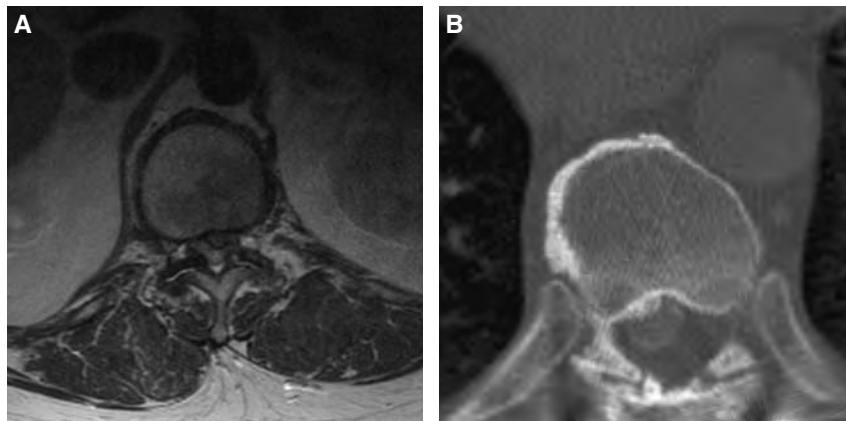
A, Axial T-2 weighted MRI image of a patient who presented with worsening lower extremity spasticity and gait disturbance caused by a large central-paracentral thoracic disc herniation. B, Axial CT scan that demonstrates the large herniation compressing upon the thoracic spinal cord.
